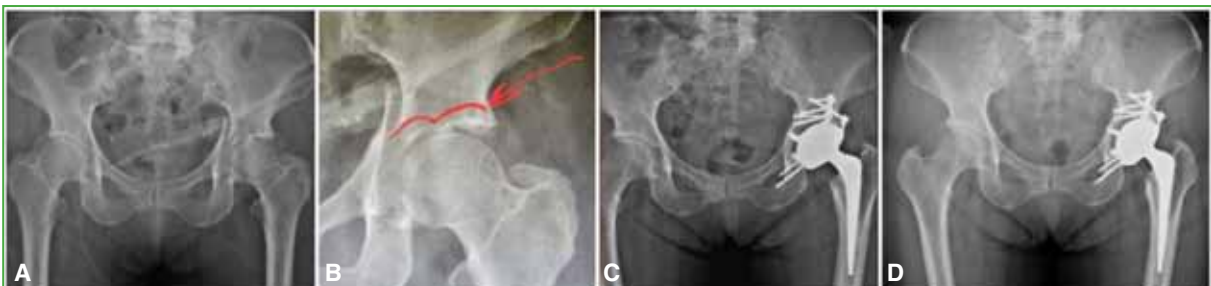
75-year-old woman with a transverse and posterior wall fracture of the left acetabulum. A. Anteroposterior radiograph of the pelvis. B. Magnified radiograph showing the “gull sign” due to impaction of the acetabulum bearing zone. C. Anteroposterior radiograph of the pelvis in the immediate postoperative period, with osteosynthesis of the posterior wall and column and hybrid total hip arthroplasty with a dual-mobility cup. D. Anteroposterior radiograph of the pelvis 3 years after surgery, showing very good clinical and radiographic evolution.
